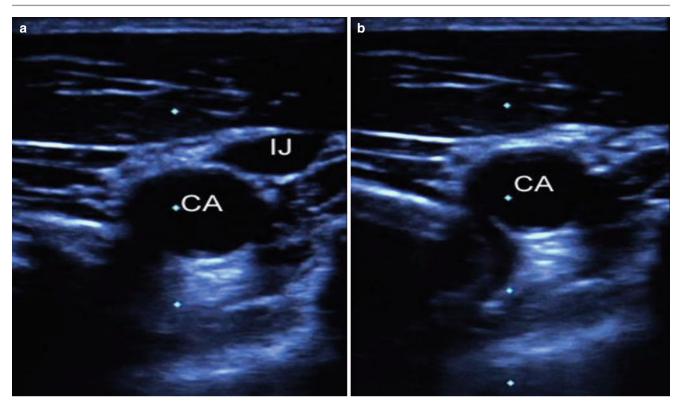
Ultrasound image of internal jugular (IJ) vein and carotid artery (CA) with the ultrasound probe lightly touching the skin (a) and with gentle pressure compressing the IJ vein but maintaining the diameter of the CA (b)
